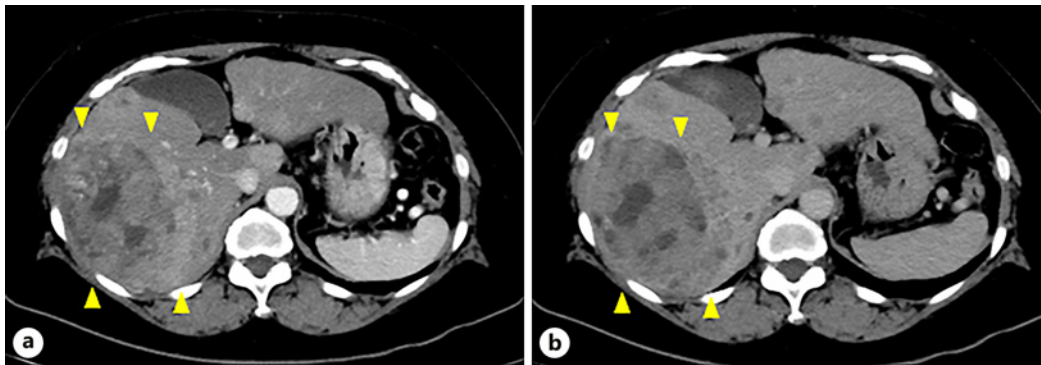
CT scan before treatment for hepatocellular carcinoma. a Early phase. b Late phase. Multiple nodules in the liver, including a nodule up to 10 cm in the right lobe (yellow arrowheads).
